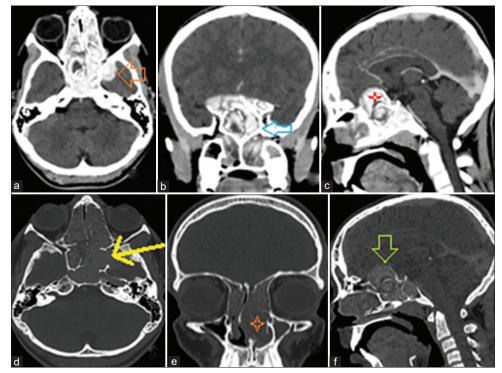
Contrast-enhanced computed tomography and bone window sections. (a) Axial section with intracranial enhancing fungal mass (red arrow). (b) Coronal section shows extension of infection in the ethmoidal region (blue arrow). (c) Sagittal section shows superior extension of fungal mass (red star). (d) Axial section in bone window shows expansion with erosion of bony outline (yellow arrow). (e) Coronal section shows expansion of the left nasal space (red star). (f) Sagittal section shows intracranial extension with bone erosion and destruction (green arrow)
